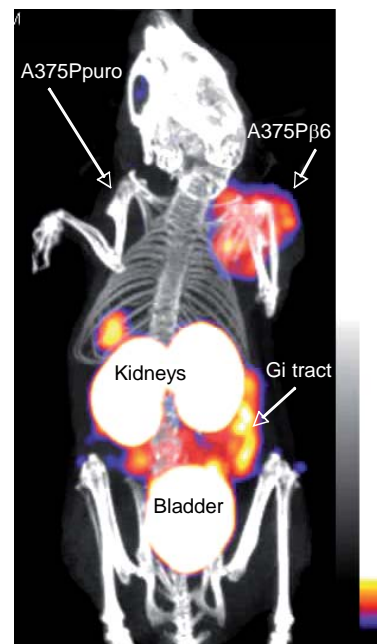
NanoSPECT/CT imaging of $\alpha v \beta 6$ -positive (A375P $\beta 6$) and $\alpha v \beta 6$ -negative (A375P Puro) xenografts with 111 Indium-labelled A20FMDV2.
